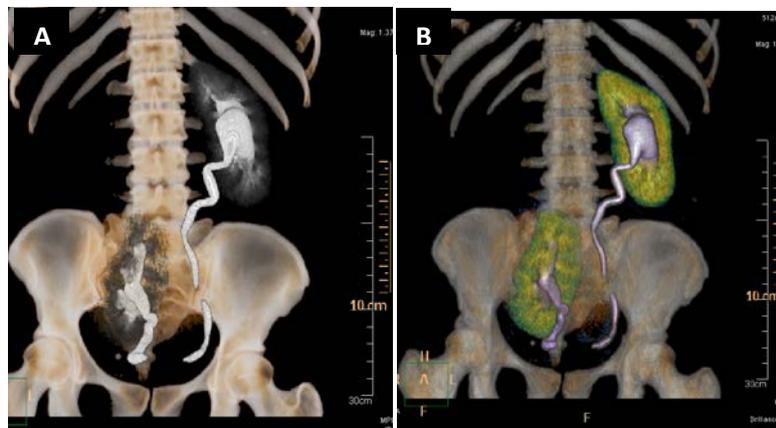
Bilateral ERS a woman of 46 years. (A) and (B) coronal CT volumetric reconstruction, excretory phase. Empty right renal fossa, ectopic right kidney iliac or lumbar and abdominal ectopic left kidney. Note the right renal axis vertical orientation and shorter right ureter and altering the rotation of both kidneys with prior arrangement your pelvis.
